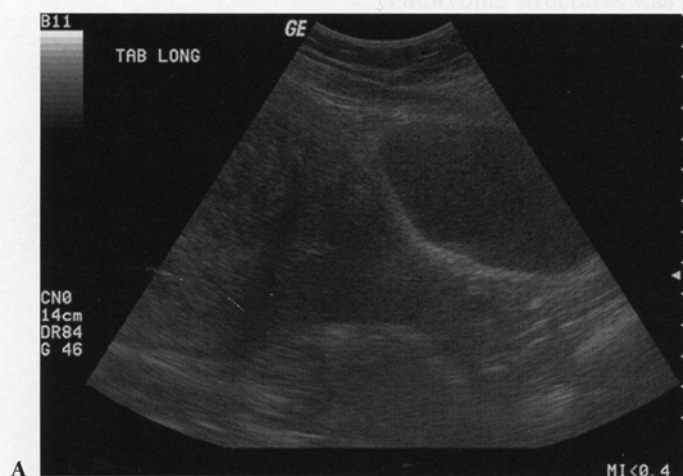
Subchorionic Hemorrhage. Reprinted from Brant WE. *Ultrasound. The Core Curriculum*. Philadelphia: Lippincott Williams & Wilkins 2001:240, with permission.
